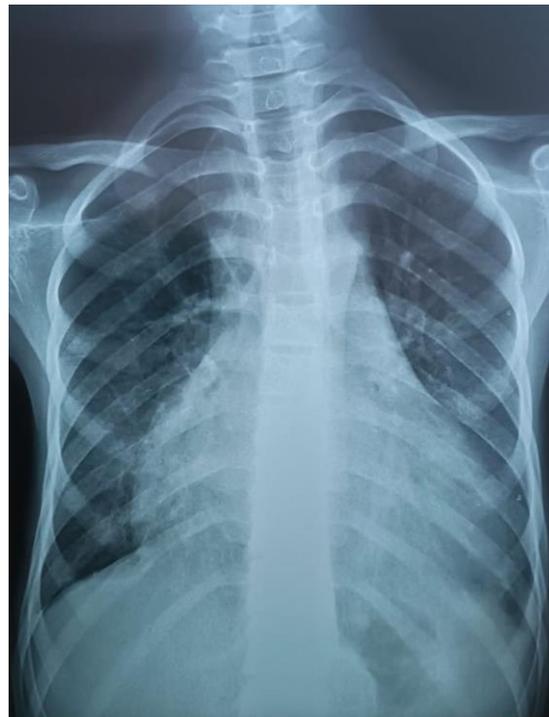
Chest x-ray showing the cardiomegaly
